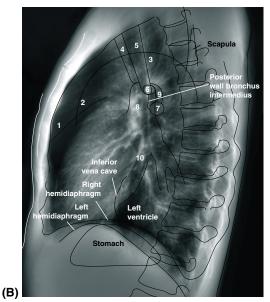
shows the normal anatomy as seen on a chest radiograph. Figure 2-14 shows a normal PA chest radiograph and a normal lateral view with the identification of significant structures.
